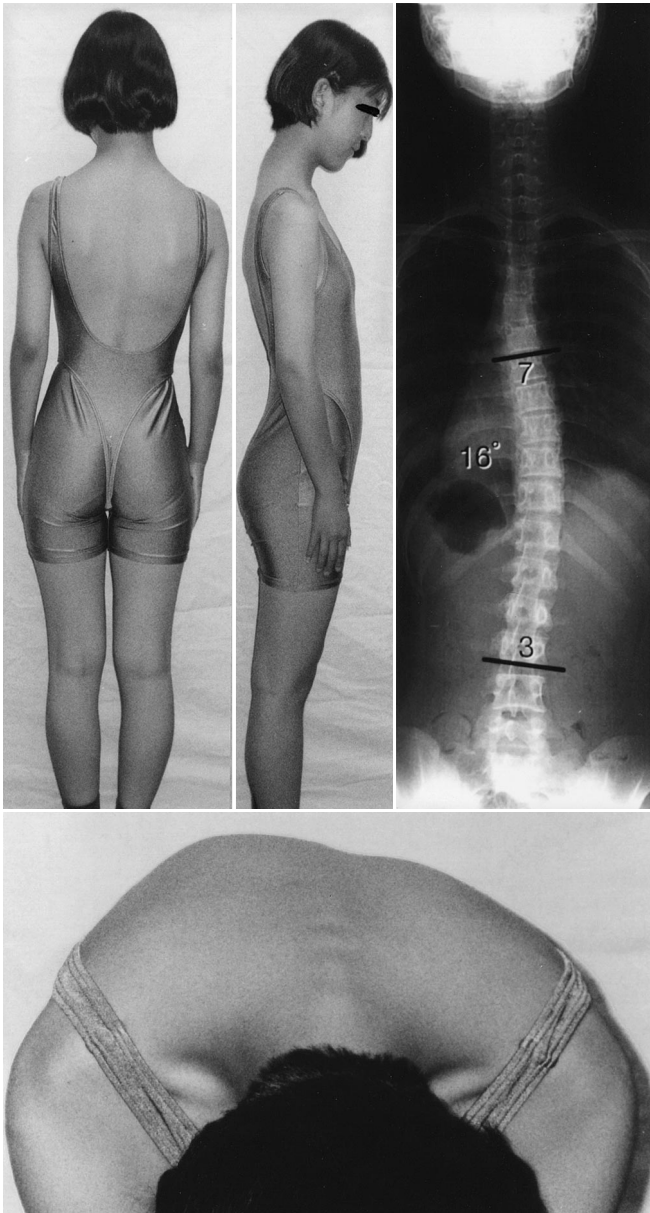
Photographs and radiograph of a 15-year-old girl (case 1)
